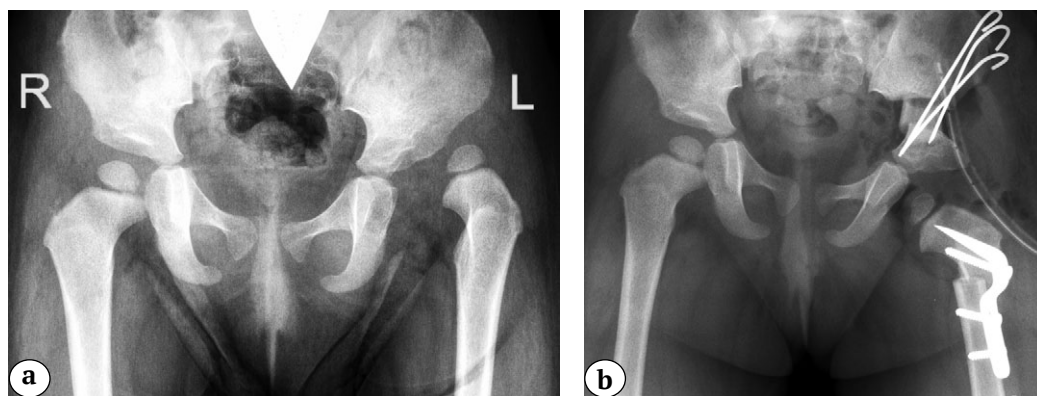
X-rays of hip joints of patient born in 2018 with hip dysplasia IHDI type IV in an anterior-posterior projection:
